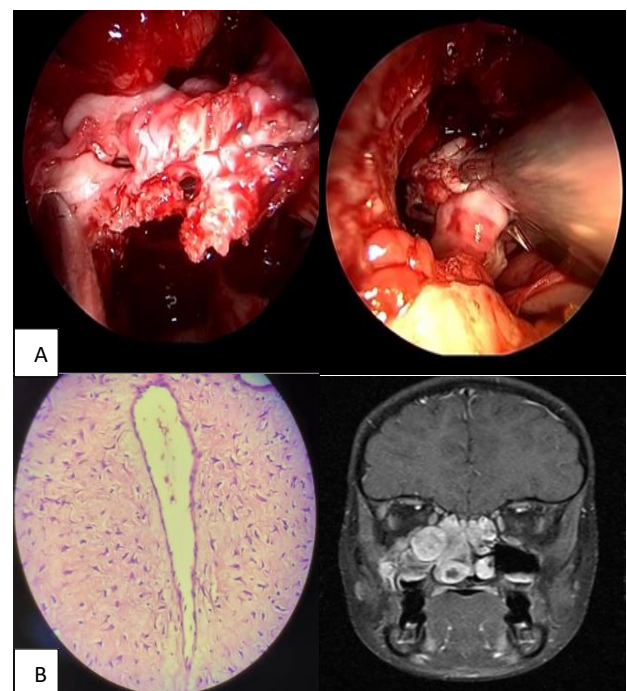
(A and B): Endoscopic images of JNA and HPE and MRI with contrast.
